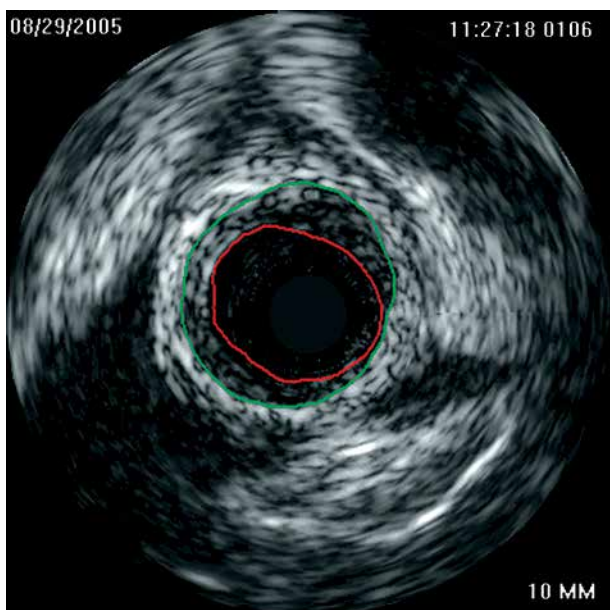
Delineation of the neointima (red line) and the external elastic membrane (green line) in a saphenous vein bypass graft ultrasonogram
